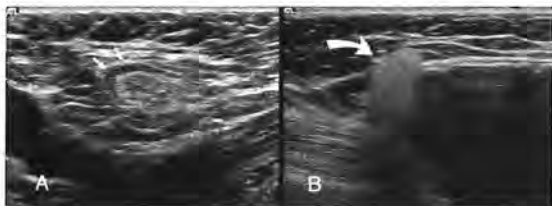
Special cases. Skin lesions, lymph nodes, and foreign bodies are also demonstrable with breast ultrasonography. (A) A typical intramammary lymph node with an echogenic hilum is shown (arrows). (B) Extracapsular spread of silicone gel from a ruptured silicone implant usually manifests itself as echogenic noise or a "snowstorm" pattern<sup>27</sup> (curved arrow).
